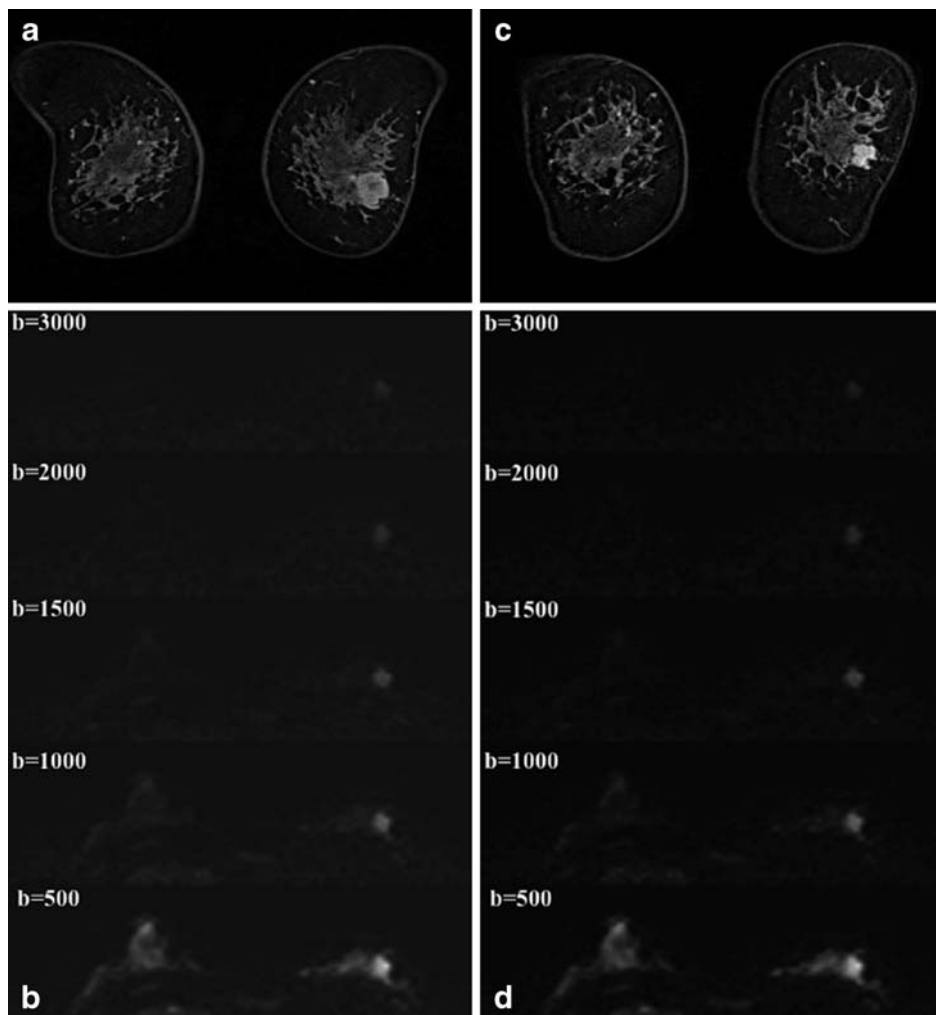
Coronal 3D fat-suppressed MR images before (A) and after (C) the second cycle of chemotherapy show an enhancing breast cancer. Transverse multiplanar reconstruction of diffusion-weighted images before (B) and after (D) the second cycle of chemotherapy shows high-signal-intensity mass. Despite the decrease in tumor size due to the chemotherapeutic effect, the lesion after the second cycle of chemotherapy had a low ADC values ($0.73 \times 10^{-3} \text{ mm}^2/\text{s}$) similar to the pre-therapy value ($0.81 \times 10^{-3} \text{ mm}^2/\text{s}$).
